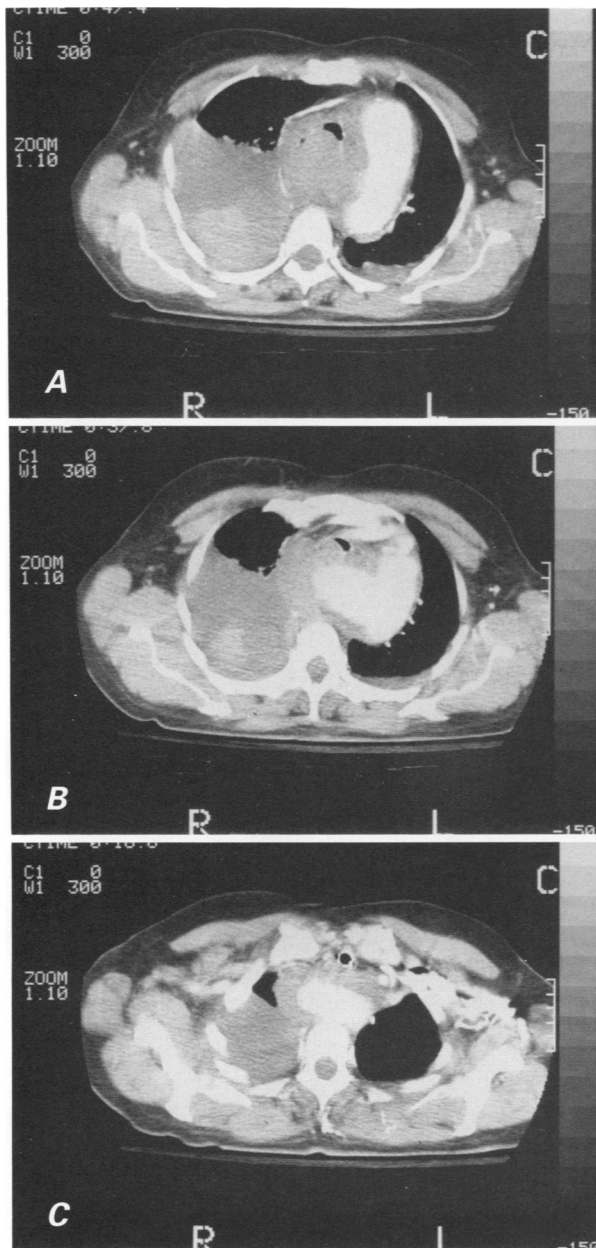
A) Computed tomographic (CT) scan showing contrast material in the aortic arch and a large mass filling the right side of the chest. B) CT scan showing a Kommerell diverticulum (origin of an anomalous right subclavian artery aneurysm), which courses to the right side of the chest posterior to the esophagus and trachea. The right chest mass is also revealed. C) CT scan showing a large right subclavian artery ascending to the thoracic outlet. D) Aortic arch arteriogram showing the angiographic catheter representing the aortic arch: a large, outpouching Kommerell diverticulum emanates from the aortic arch; the left subclavian and the right and left common carotid arteries are faintly silhouetted.
